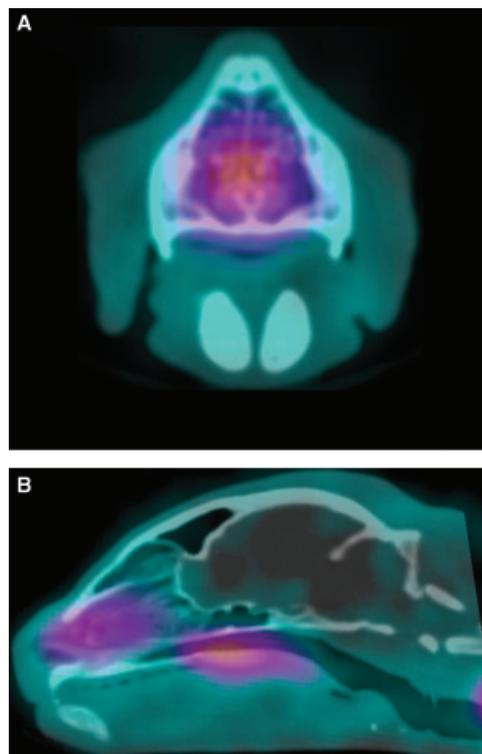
Transverse (A) and sagittal (B) fused CT and single photon emission computed tomography image. Note focal ^{99m}Tc activity in the nasal cavity and nasopharynx.
